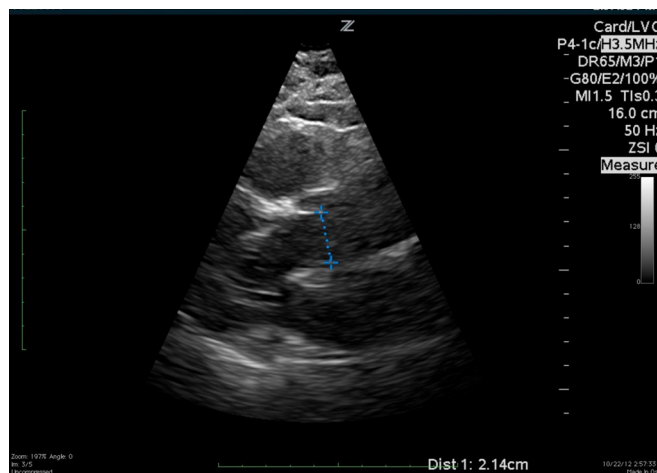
Ultrasonographic image of heart measuring left ventricular outflow tract diameter (LVOTD).
